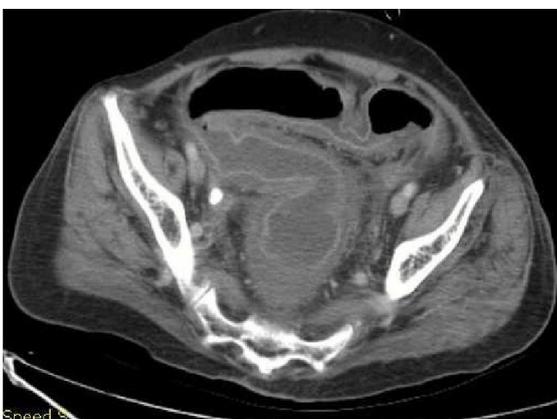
(a) CT- Inflammatory disease involving the entire colon
